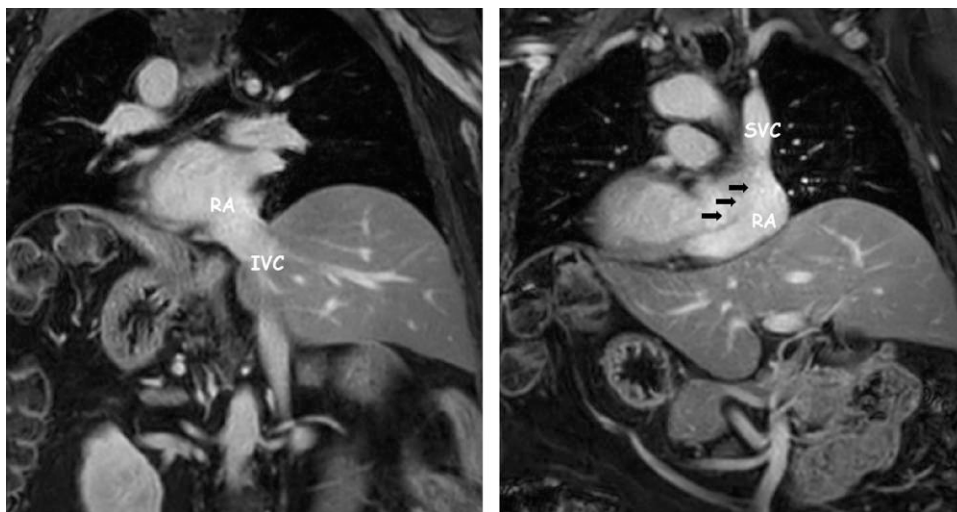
MRI evaluation before the interventional procedure showing the position of IVC and SVC with respect to the atrial septal aneurysm (black arrows). IVC, inferior vena cava; SVC, superior vena cava; RA, right atrium.
